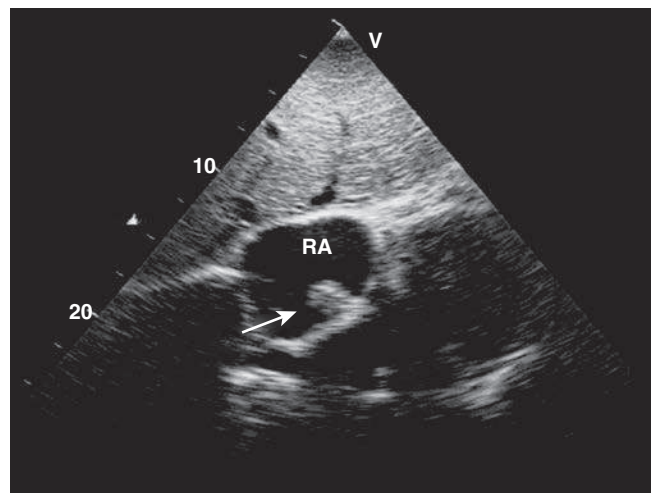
Right atrial thrombus. Subcostal echocardiographic view of the right atrium (RA) in a patient with a modified classic Fontan for D-transposition of the great arteries, multiple muscular ventricular septal defects, a functional single ventricle, and atrial tachyarrhythmias. The arrow indicates a well-delineated thrombus in the dilated right atrium. (From Khairy P, Poirier N, Mercier L-A. Univentricular heart. *Circulation*. 2007;115:800-812.)
